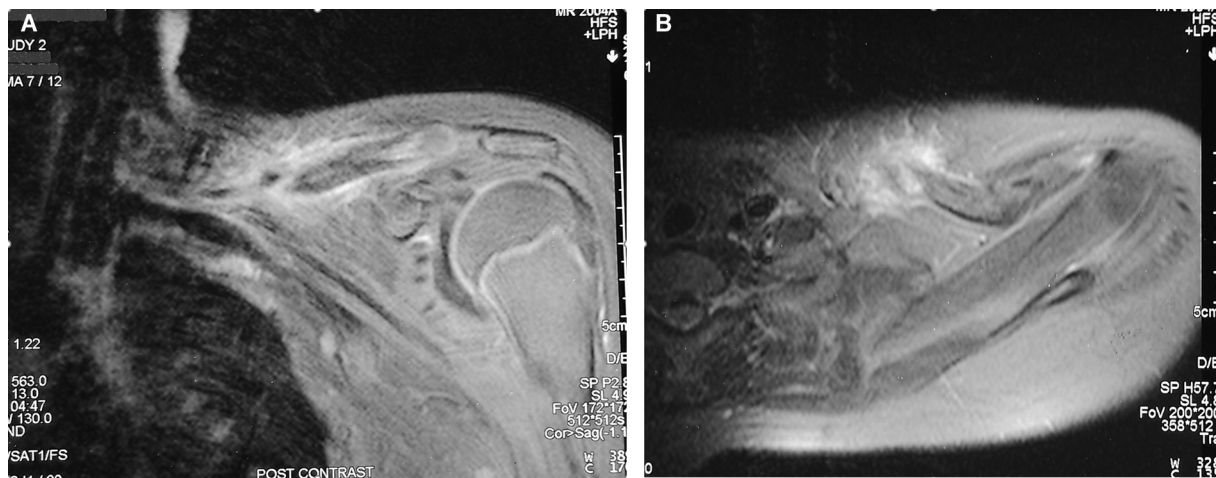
(A) T1-weighted magnetic resonance imaging (MRI) coronal image acquired following administration of intravenous Gadolinium agent showing heterogeneous contrast enhancement along with ill-defined adjacent soft tissue component; (B) T2-weighted MRI axial image showing hyperintense signal intensity. Soft tissue component was seen abutting the mediastinal fat in the prevascular space.
